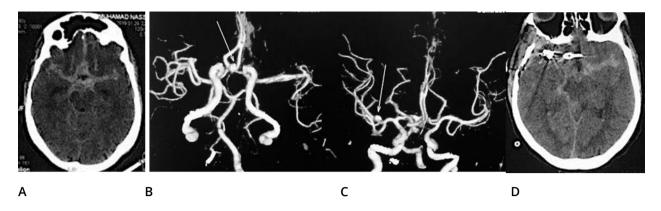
A 39-year-old male patient with autosomal dominant polycystic kidney disease (ADPKD) presented to the emergency department with a sudden-onset, severe headache and vomiting followed by an altered level of consciousness (GCS:10-E2M5V3). A: An initial cranial CT scan showing SAH in the basal cisterns (the typical star-shape sign) with no clue to the source of bleeding. B and C: A cerebral CT angiography- 3D reconstruction- revealing multiple intracranial saccular aneurysms in the Acom (B inferior view with an arrow pointing to the Acom aneurysm) and the right MCA (B anterior view with an arrow on the superiorly directed, right MCA aneurysm); both aneurysms are regular, rounded-shaped, have no murphy's teat and, have a size of 7 mm each with no vasospasm noticed. D: An early, post-operative cranial CT scan showing 2 clips in position with no other significant findings
